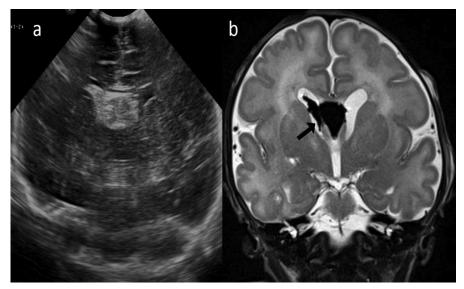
Coronal ultrasound scans of the head (a) and MRI coronal T2w image (b) at diagnosis. The images show an intraventricular hemorrhage and a dilatated cavum septum pellucidum with a large clot inside (arrow).
